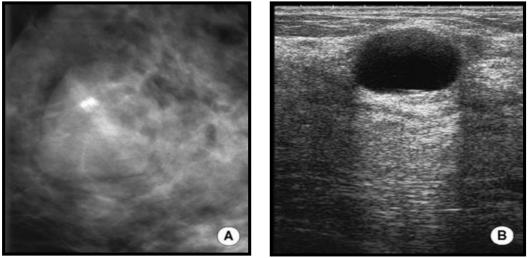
Mammography shows: well defined rounded mass with typical halo sign (A), Ultrasounds shows rounded anechoic cyst (the absence of internal echoes and posterior enhancement is diagnostic of the cyst)
